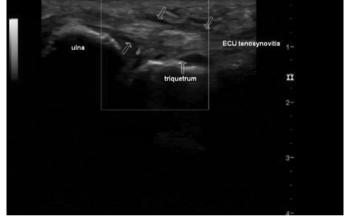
Ultrasonography of extensor tenosynovitis in the wrist joints
